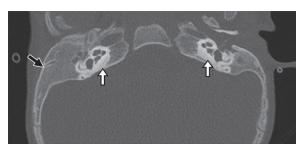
CHARGE syndrome with sensorineural hearing loss in an 18-year-old woman. (a, b) Axial (a) and coronal (b) CT images show left-sided choanal stenosis (arrow in a) and cleft palate (arrow in b). (c, d) Axial temporal bone CT images show bilateral absence of the lateral semicircular canals (arrowhead).
